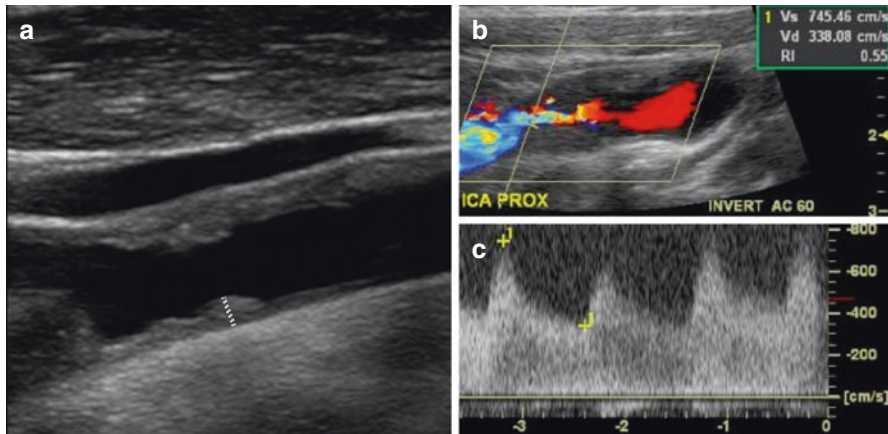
Ultrasound imaging of carotid plaque. Ultrasound in a patient with severe carotid stenosis. B mode (grayscale) ultrasound image (a) of the right common carotid artery just proximal to the carotid bifurcation in the longitudinal plane demonstrates mildly echogenic atherosclerotic plaque along the vessel wall with intima to media thickness (IMT) measured by the dotted line. Color Doppler ultrasound at the level of severe stenosis (b) shows high systolic velocity of 745.46 cm/s. M-mode ultrasound (c) also demonstrates elevated PSV, spectral broadening and aliasing are additional criteria supportive of high grade stenosis
